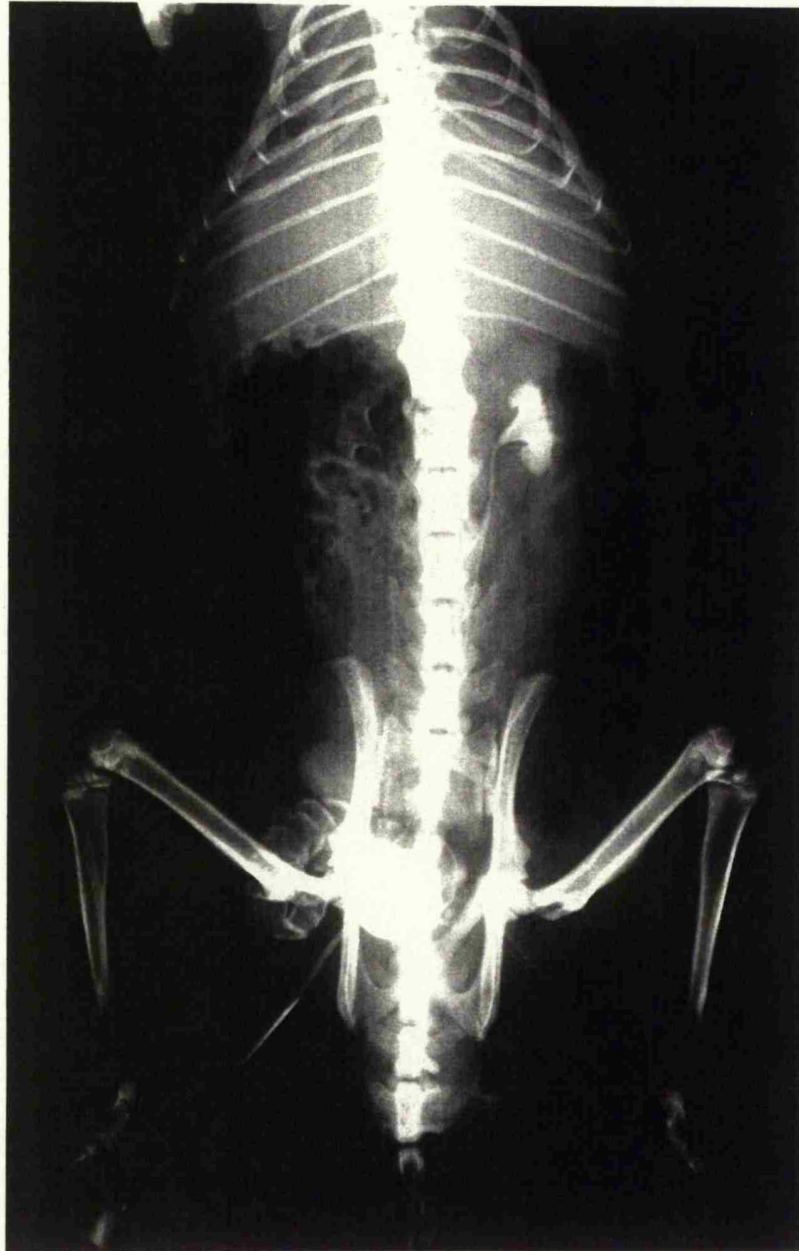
Another example of an Xray demonstrating a patent vas deferens with filling of the right seminal vesicle
